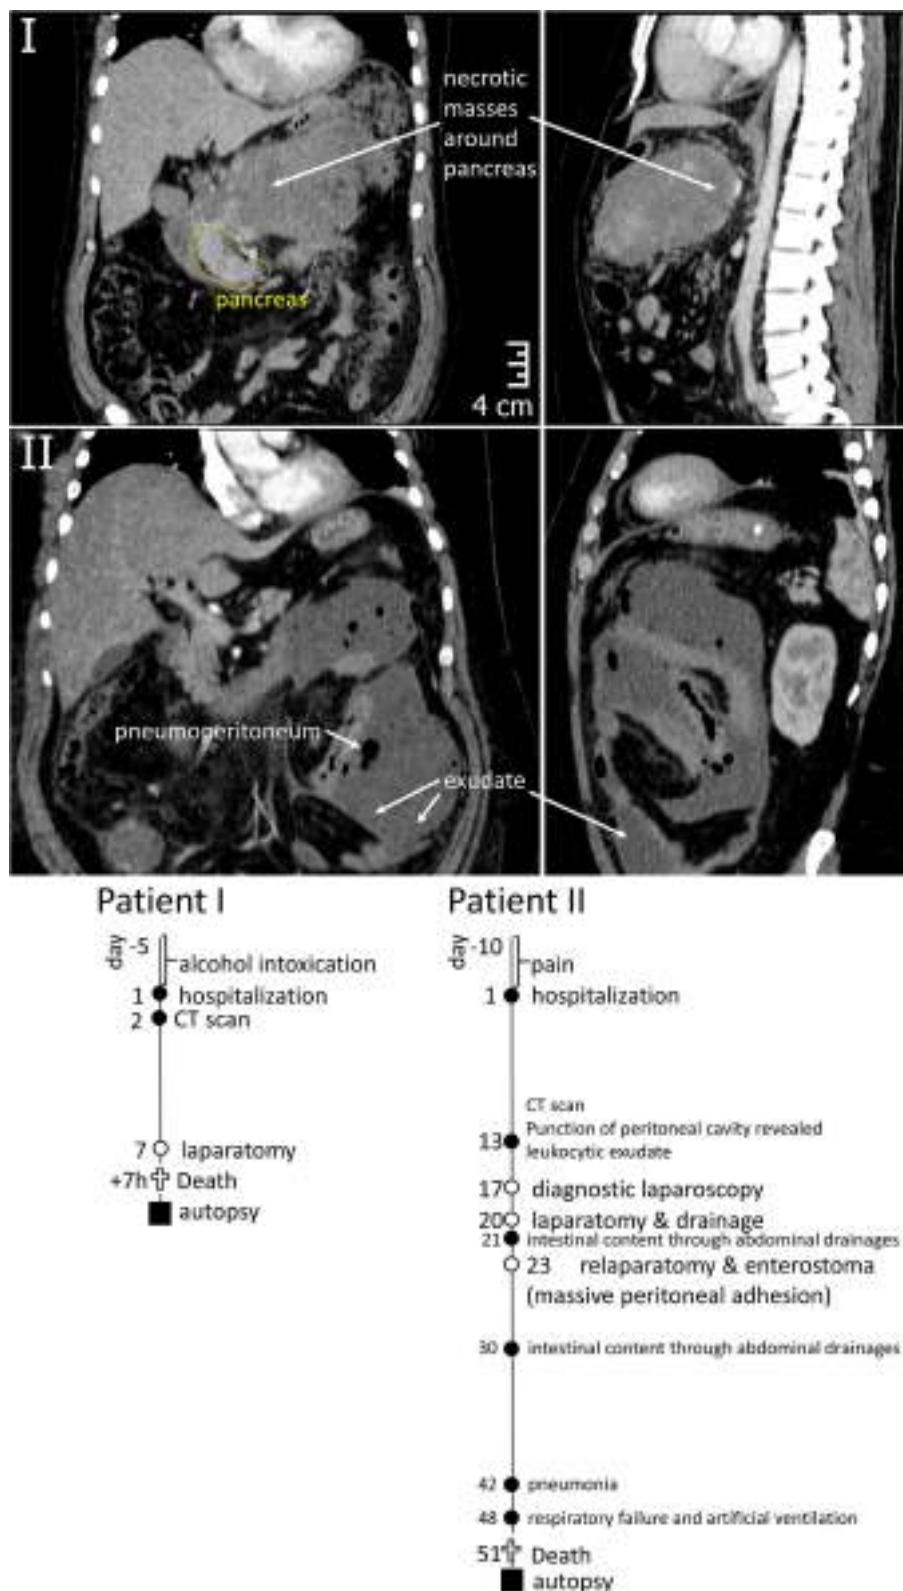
Top – CT images of the abdominal region of Patients I and II demonstrating the areas of inflammation around pancreas (I) and in peritoneum (II). Bottom – graphical representation of disease courses of Patients I & II. Important events are indicated with filled circles, operations – open circles, time of sample collection – filled squares.
